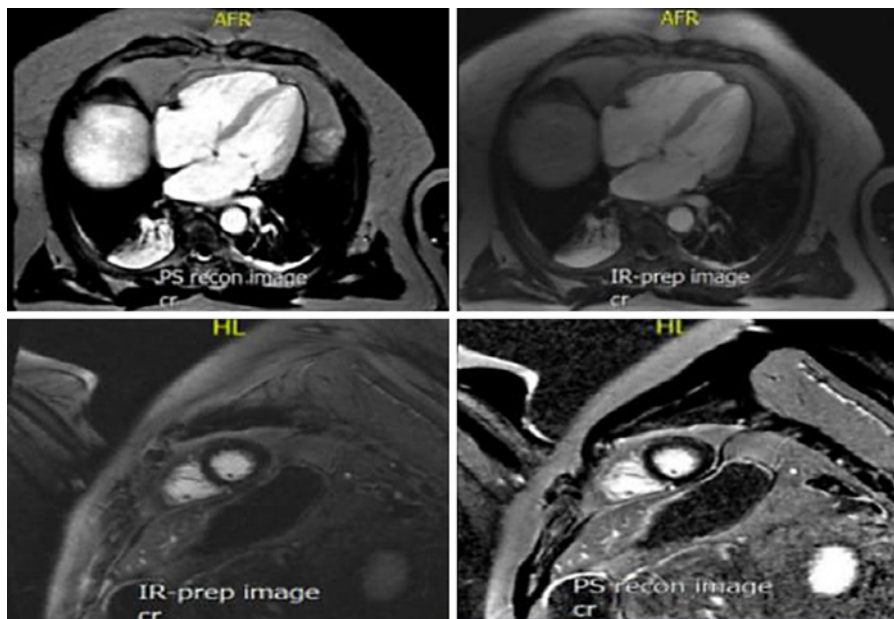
Cardiac magnetic resonance imaging. No signs of edema, fibrosis, or chronic inflammatory process at the myocardial level.
